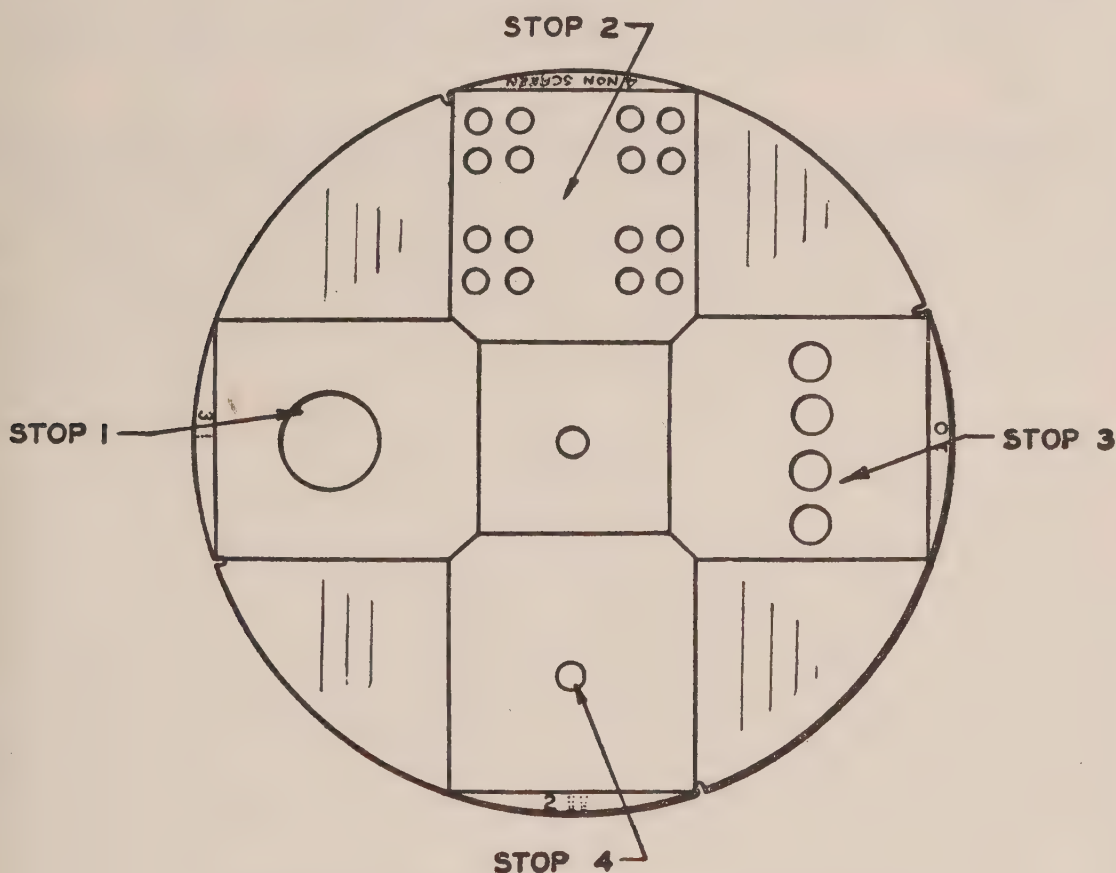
Stops employed for table x-raying.
